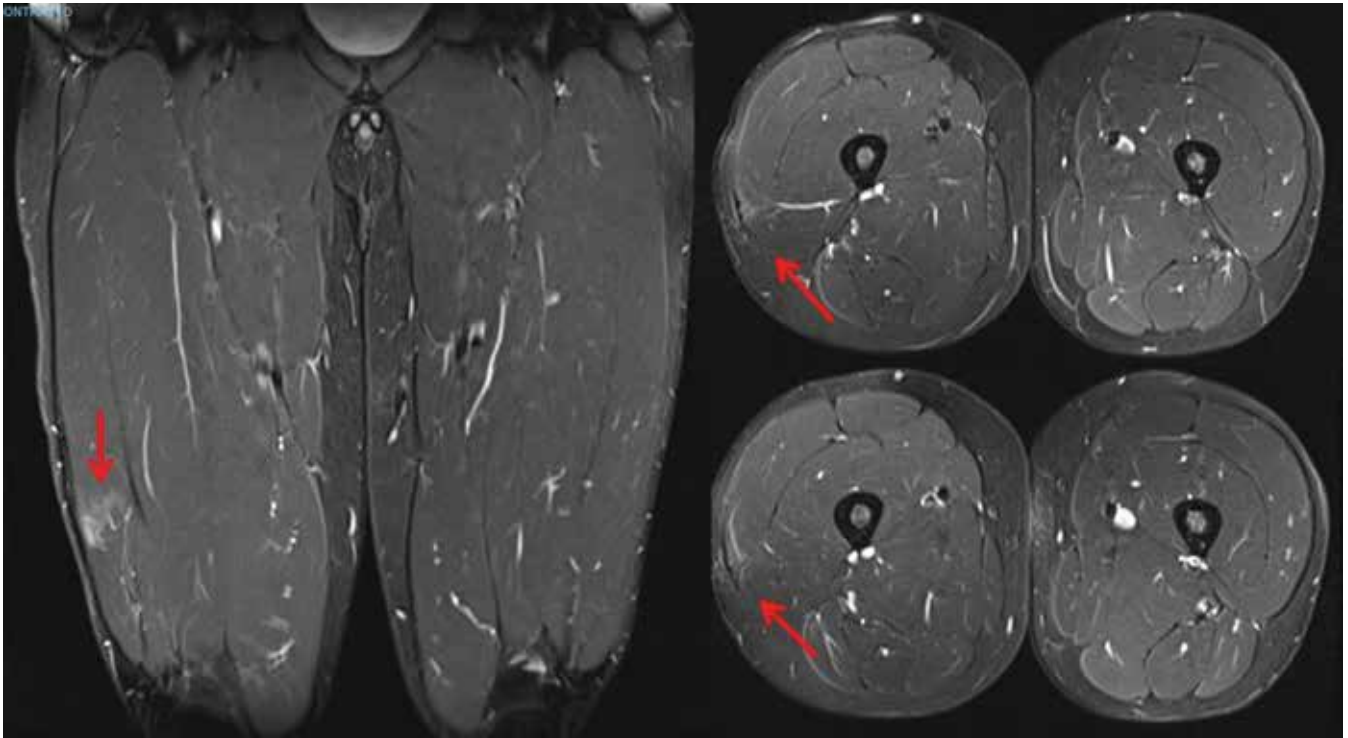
MRI scan 1 year post-injury. The patient returns to play volleyball at the pre-injury level pain free.
